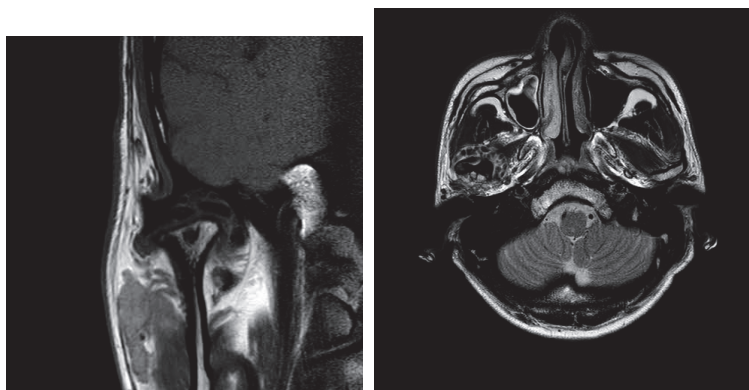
Coronal view of magnetic resonance (MR) TMJ T1-weighted image, showing a mass extending to the cranial base. The coronal view shows flattening of the right condylar head with a heterogeneous signal intensity, particularly in the cortical and subcortical areas, which may indicate sclerosis or degeneration. The articular disk of the right TMJ appears to be displaced anteriorly.
